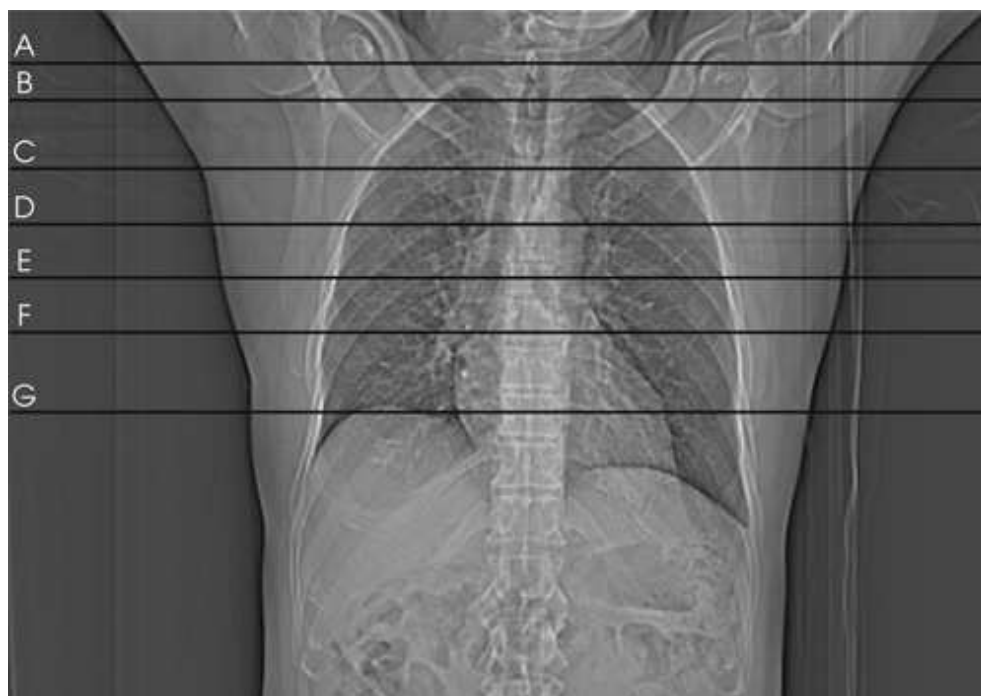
CT localizer (scout) image of thorax.
